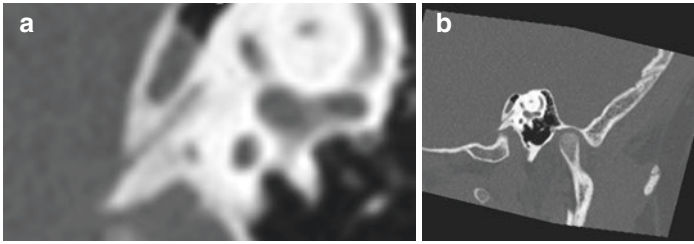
Sagittal oblique computed tomography (CT) images without (a) and with (b) magnification show that the anatomical margins become blurred with magnification
